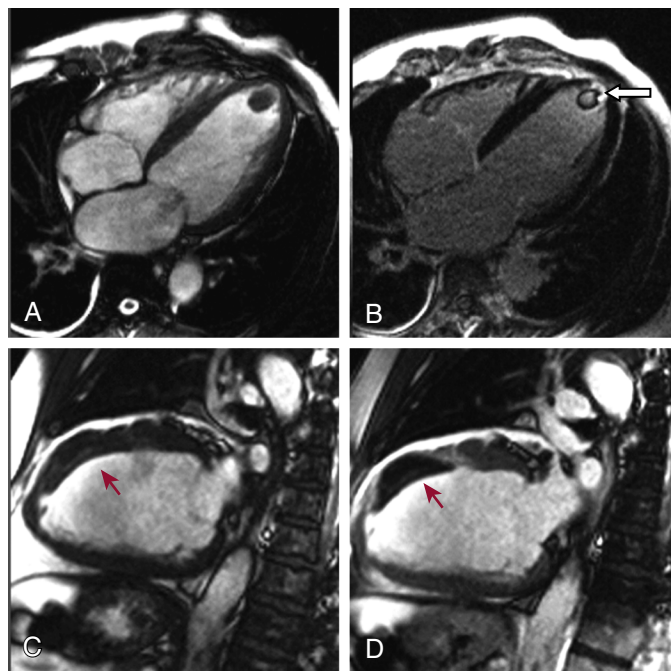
Intracavitary thrombus is recognized as a filling defect separate from papillary muscles and trabeculae on the four-chamber cine view (A) and is noted on the delayed enhancement image (B) to be adherent to a site of previous apical infarction (*white arrow*). Thrombus may sometimes have an “etched” appearance on delayed-enhancement cardiac magnetic resonance images obtained with a standard inversion time, but will be homogeneously dark on images with a long inversion time (550 to 600 ms). In another patient with a mural thrombus lining a true aneurysm of the anterior wall, the precontrast two-chamber cine steady-state free-precession image (C) does not clearly differentiate the thrombus (*red arrow*) from the myocardium, because their signal intensities are similar. (D) The postcontrast inversion-recovery steady-state free-precession image with a long inversion time (600 ms) allows clear differentiation of thrombus from myocardium. Echocardiography did not detect this thrombus. For an additional presentation of this image, click here.
